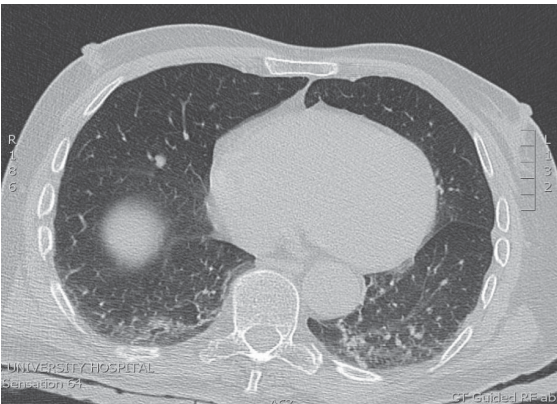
Computed tomography scan of a patient with healthy lungs during general anaesthesia. The slice shown is immediately cephalad to the right diaphragm. Bilateral atelectasis is seen, which becomes progressively more dense on moving from the non-dependent (anterior) to dependent (posterior) regions.
